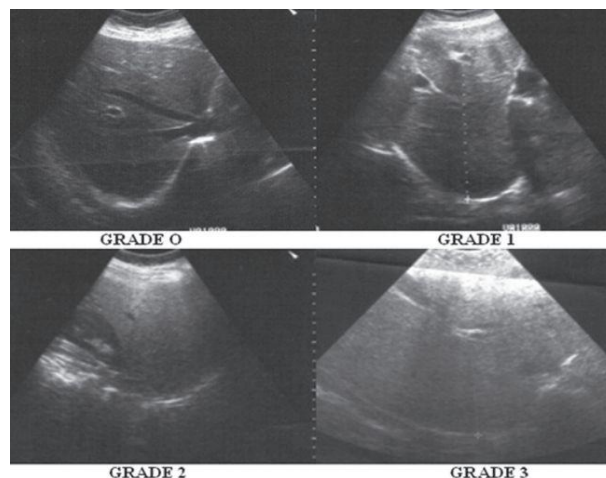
Ultrasonographic fatty liver stages. Grade 0 - no fatty liver, Grade 1- mild fatty liver, Grade 2 - moderate fatty liver, Grade 3 - severe fatty liver.
